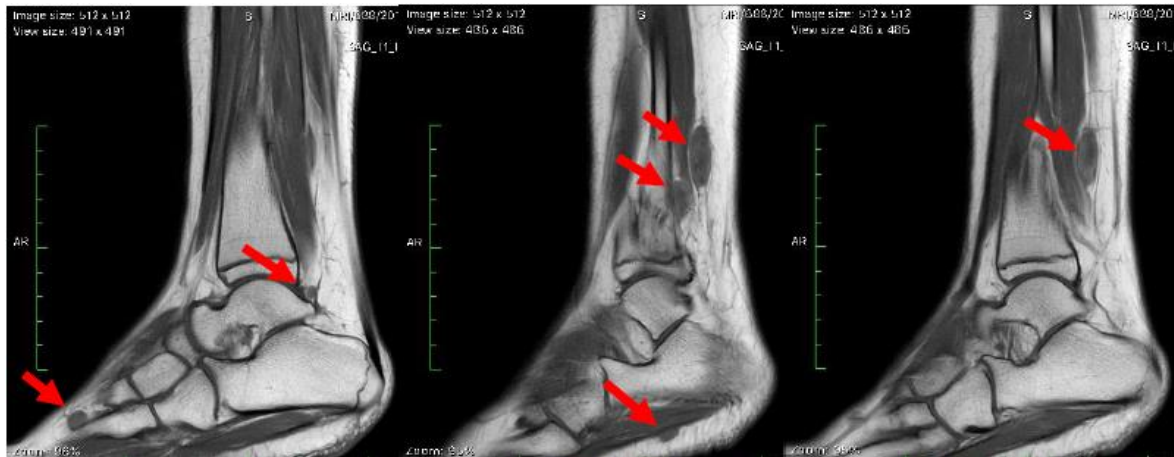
Axial view of T1-weighted image (T1WI) showed multiple lesions of varying sizes (as marked by red arrows) in the right leg and foot which appeared isointense to muscle.
